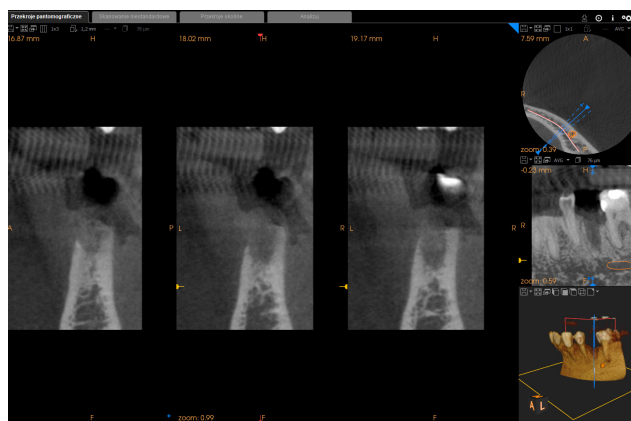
Cone beam computed tomography before implant treatment, 4 months after the extraction of tooth 35
